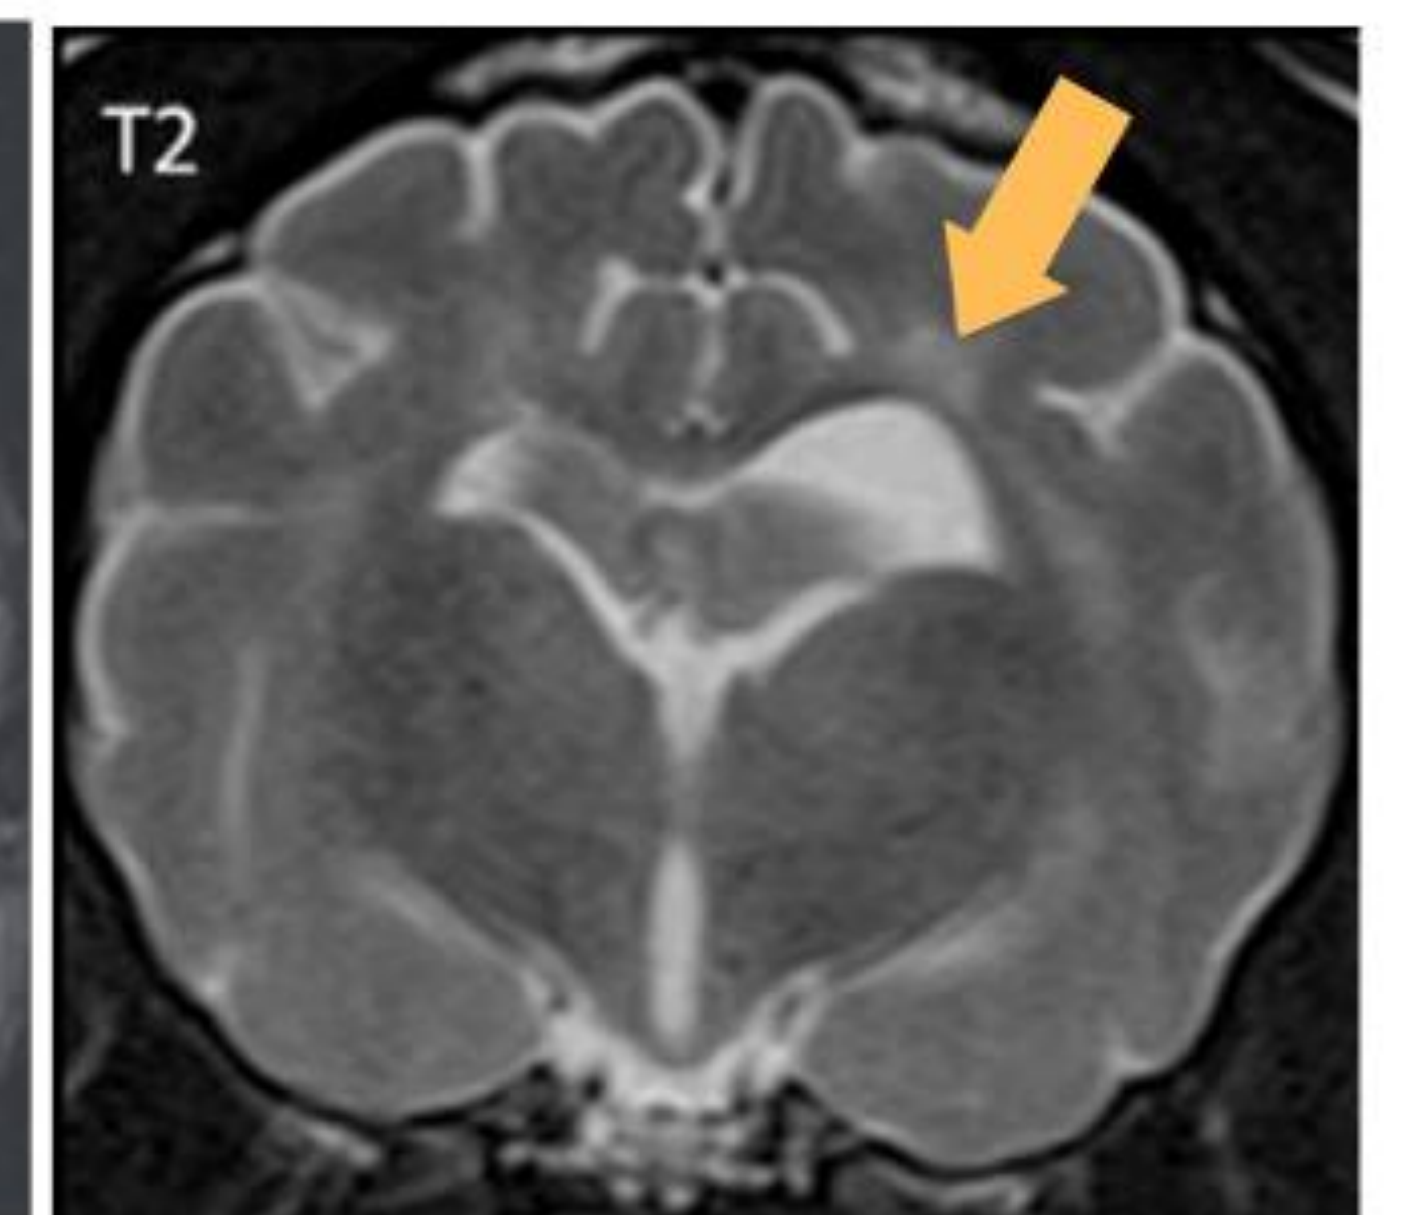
MRI of the encephalon with an hyperintense area over one of the ventricles, known as leukoaraiosis (Dewey *et al.*, 2019).
